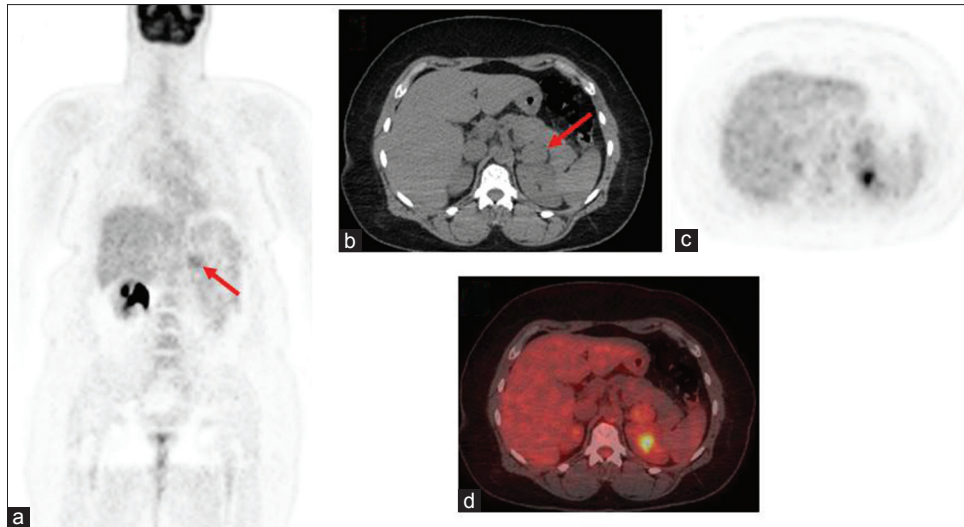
Coronal whole-body ¹⁸fluorodeoxyglucose positron emission tomography computed tomography (a), axial computed tomography (b), axial positron emission tomography (c), and fused axial positron emission tomography/computed tomography (d) showing an well-defined 3.4-cm mass lesion (red arrow) involving the left adrenal region that has an standardized uptake value average of 1.7 with an average hounsfield unit of 37; its standardized uptake value average is slightly higher than the liver standardized uptake value average which is 1.2 that would be in favor of neoplastic process rather than benign adrenal adenoma
